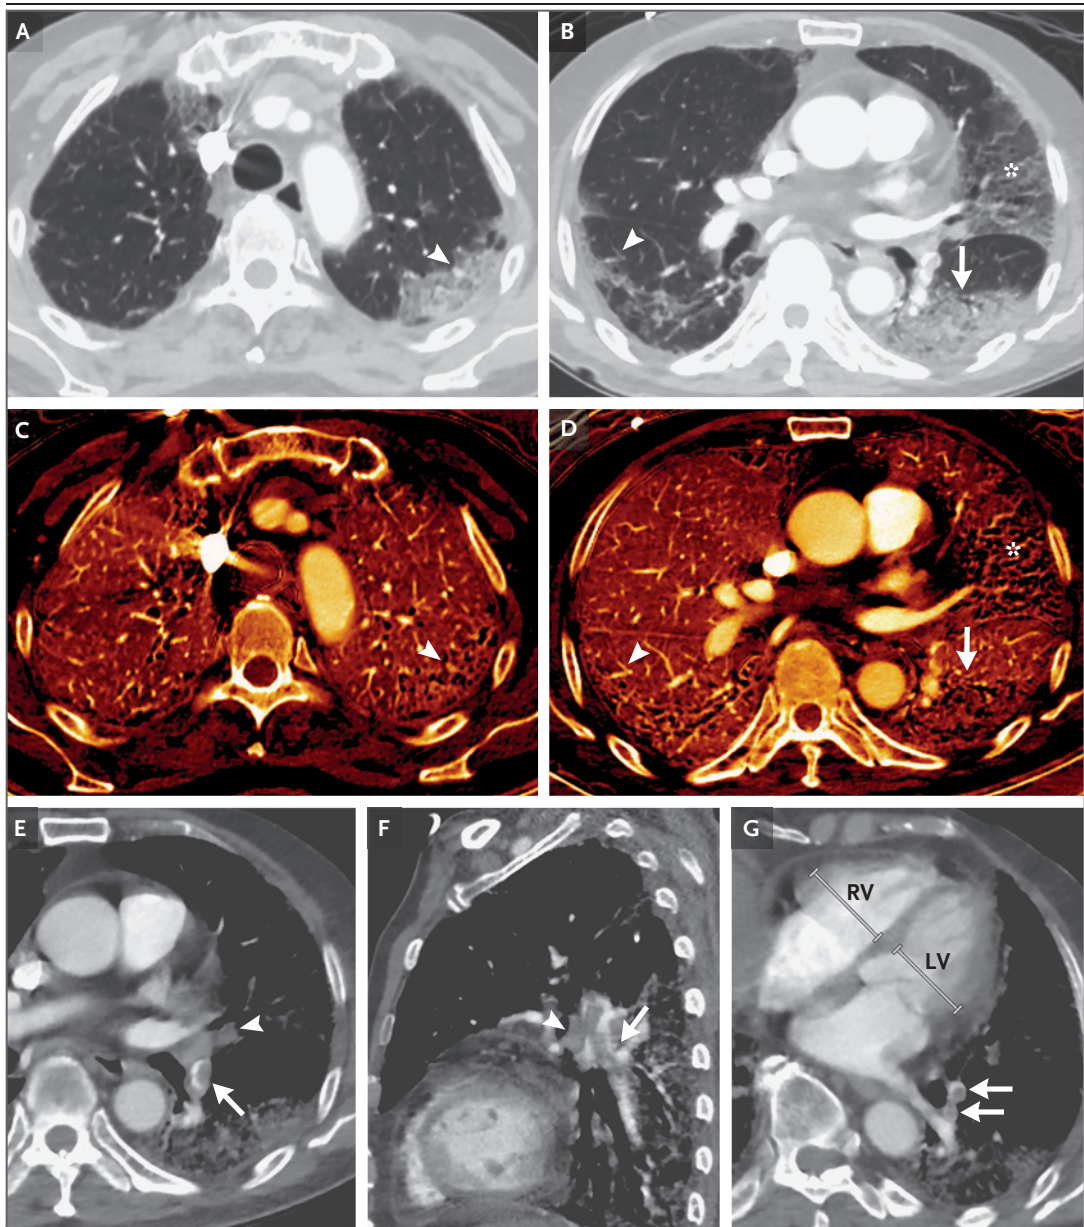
CT of the Chest.
